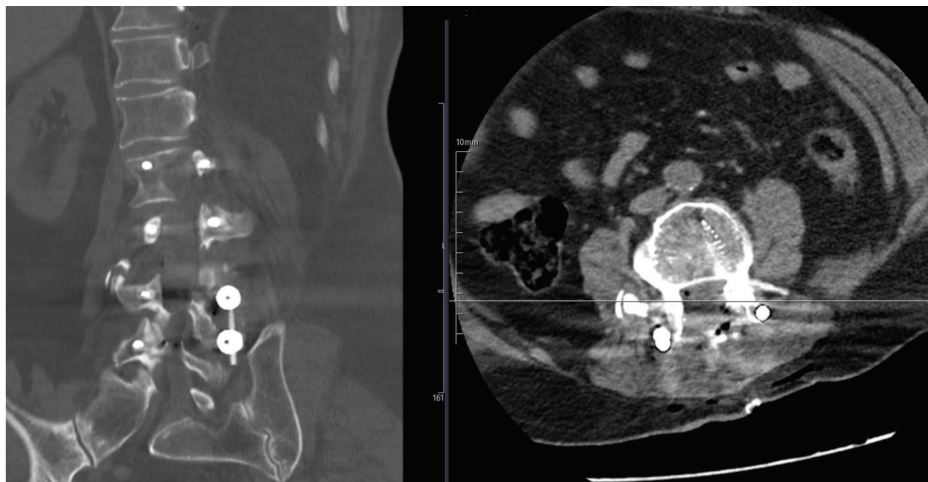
Postoperative CT images demonstrating spinal instrumentation from L2 to L5 and the relationship to the bridging site
